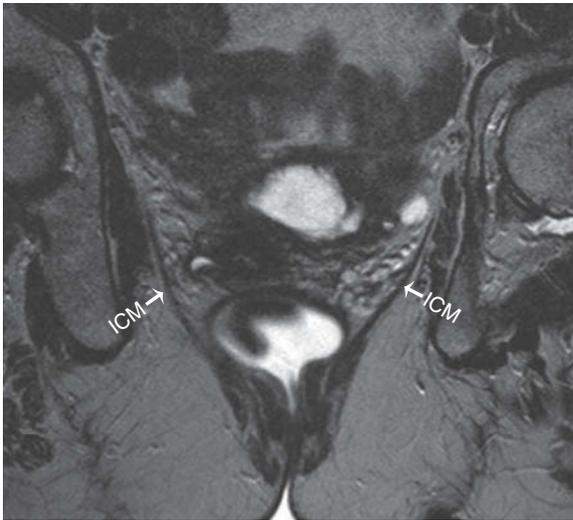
Atrophic iliococcygeus muscles in a 52-year-old female with global pelvic prolapse. Coronal T2-weighted FSE image at the level of the rectum reveals thinning and downward convexity of the iliococcygeus muscles (arrows).
